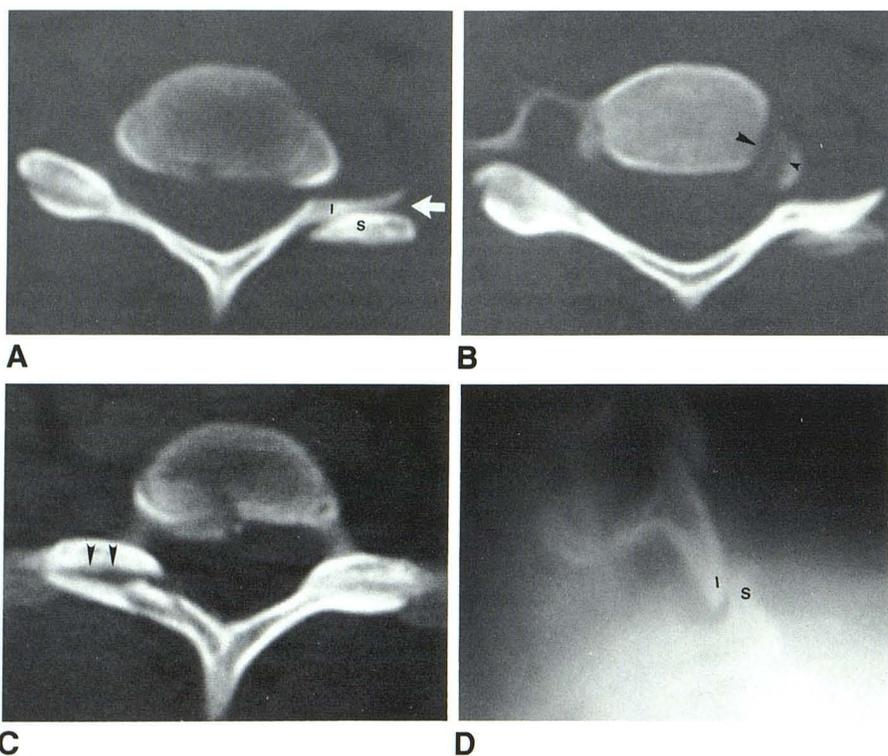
Locked facet (A, arrow). CT scans show abnormal relation of superior and inferior articular processes (A, S and I, respectively) and subluxed uncovertebral joint (B, arrowheads). Section through next lower disk level shows mildly distracted facet joint (C, arrowheads). Pluridirectional tomogram (D) confirmed locking of inferior articular process in front of superior articular process.
